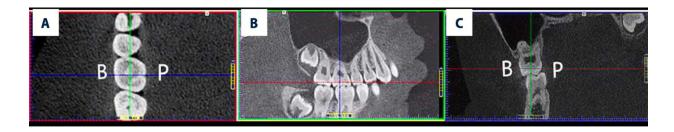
CBCT IMAGES IDENTIFYINGTHE BASELINE PLANE OF A RIGHT MAXILLARY FIRST MOLAR FOR SUBSEQUENT MEASUREMENTS OF ANATOMICAL LANDMARKS
